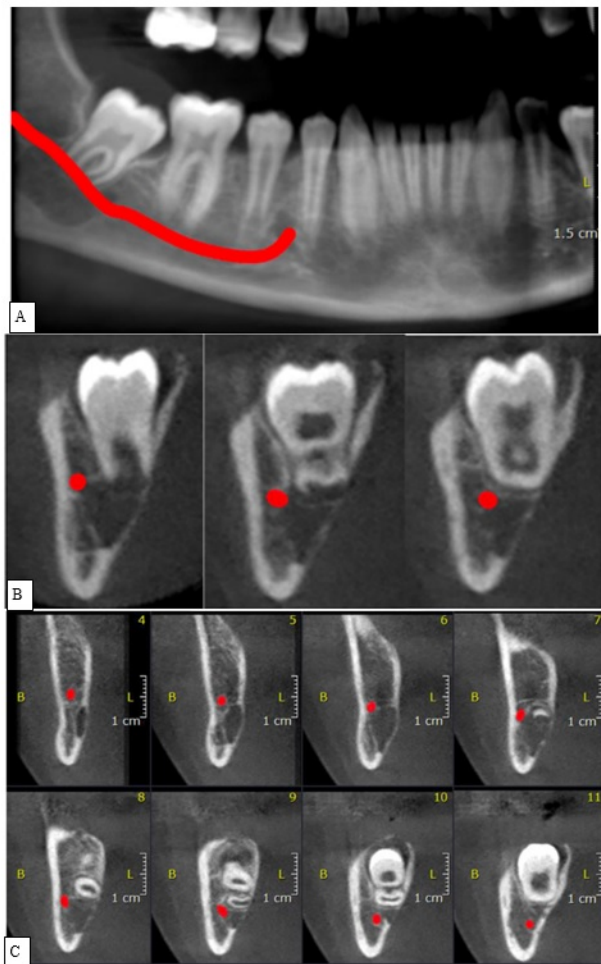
Reconstruction from the CBCT with tracing of mandibular canal (red). A): Panoramic view. B): Coronal view showing successive frames from more anterior to more posterior slices
